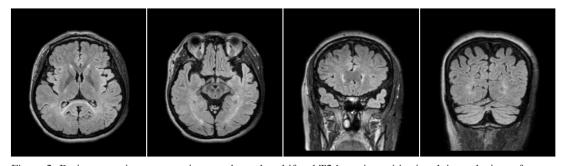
Brain magnetic resonance images showed multifocal T2 hyperintensities involving splenium of corpus callosum, both optic radiations, and both anterior and posterior lateral periventricular white matter
